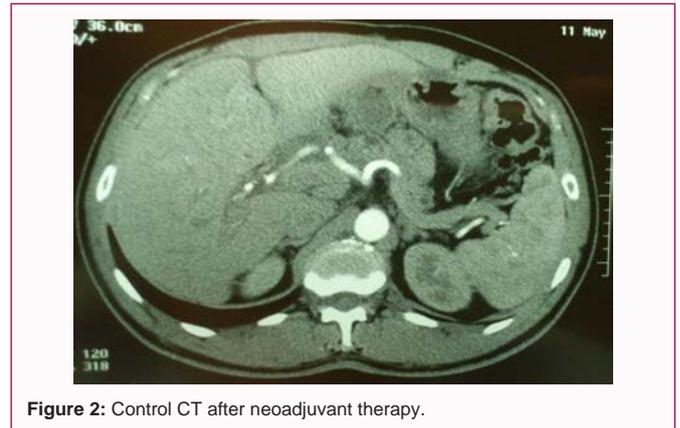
Control CT after neoadjuvant therapy.
